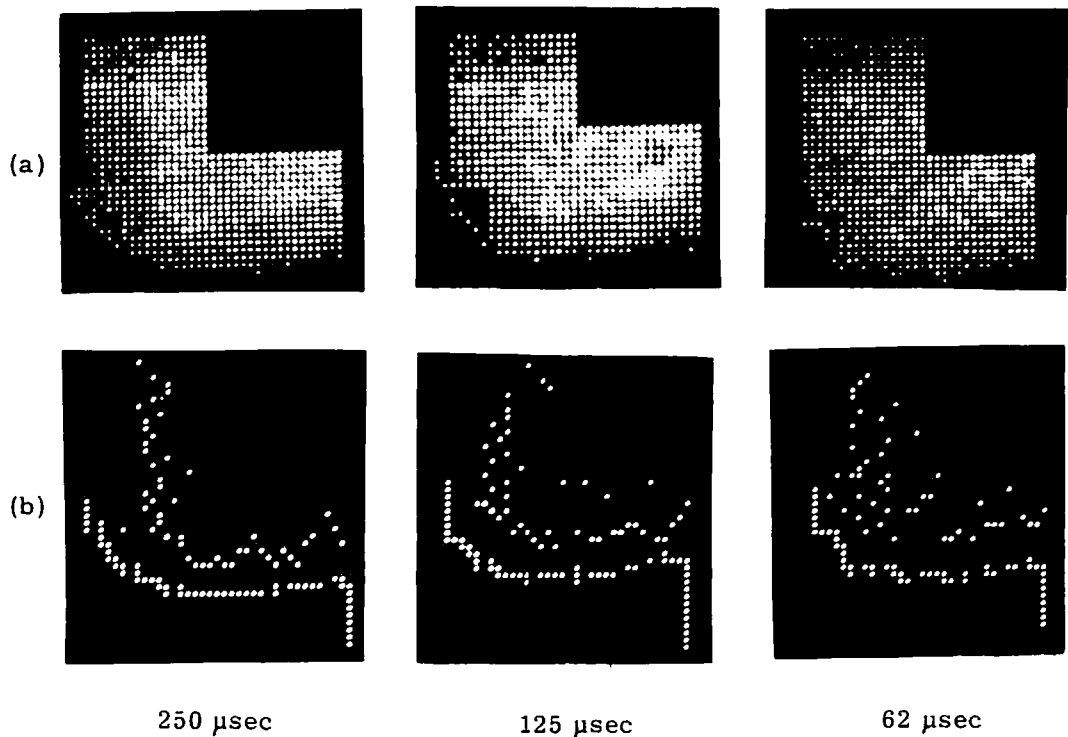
(a) X-ray images obtained with shorter exposure times (250, 125, 62 μ sec per sample point). Exposure was given only to a narrow area selected with reference to the observed position of the jaw surface.
